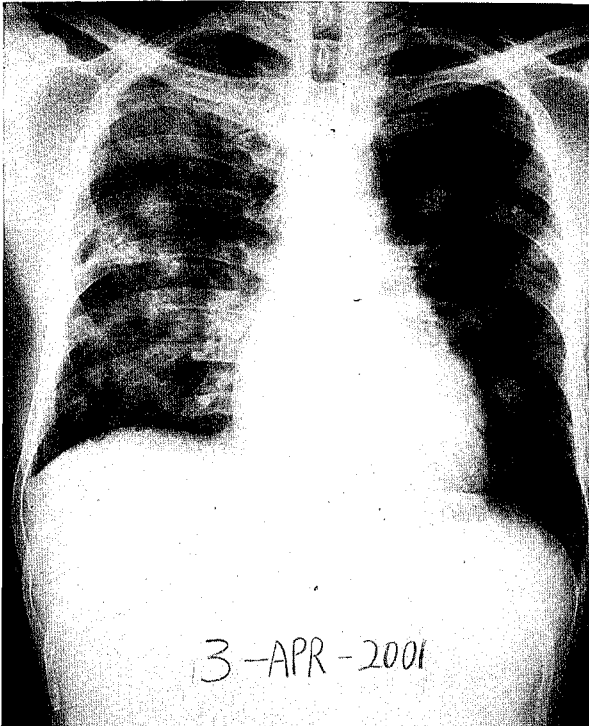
Chest X-ray shows increased infiltration in the right lung field, and right pleural effusion.
